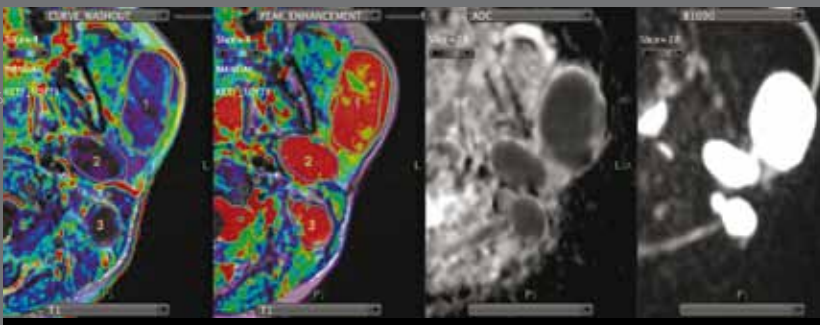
Multiparametric display: Fusion Curve-Washout/T1; Peak Enhancement/T1; ADC ; B1000 : DCE and DWI show the same behavior
